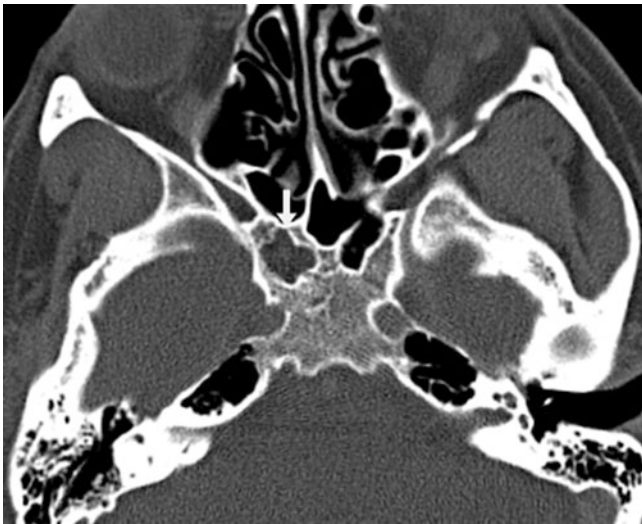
A 31 year old in whom focal fat density (*arrow*) within the right basisphenoid on CT was consistent with arrested pneumatization
